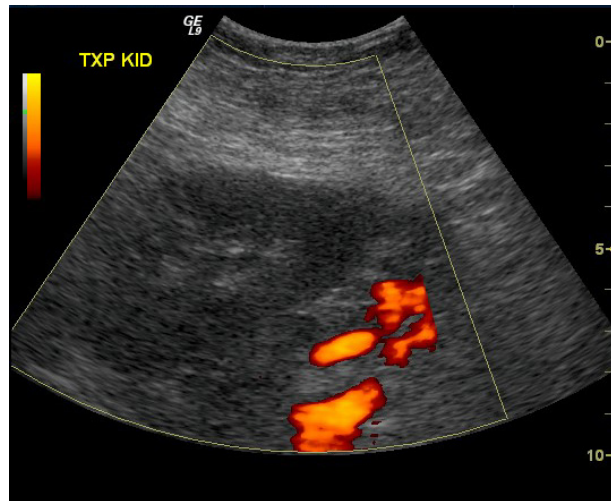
Renal artery thrombosis. Doppler US image through the transplant kidney shows no flow through the kidney or in the main renal vessels. Iliac vessels adjacent to the kidney show normal color flow.
